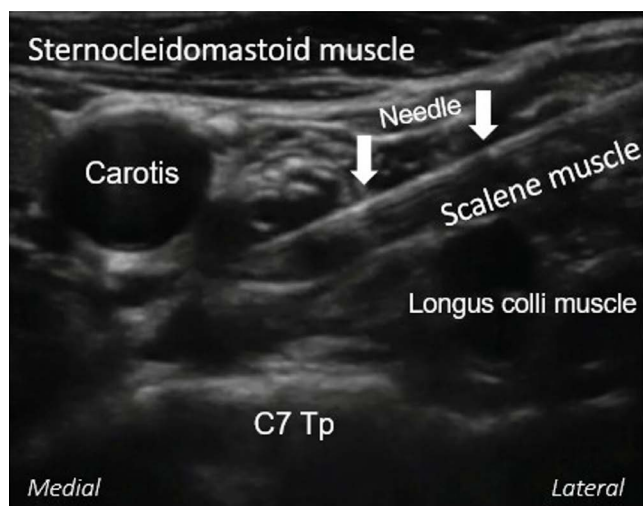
Ultrasound-guided stellate ganglion blockage.
